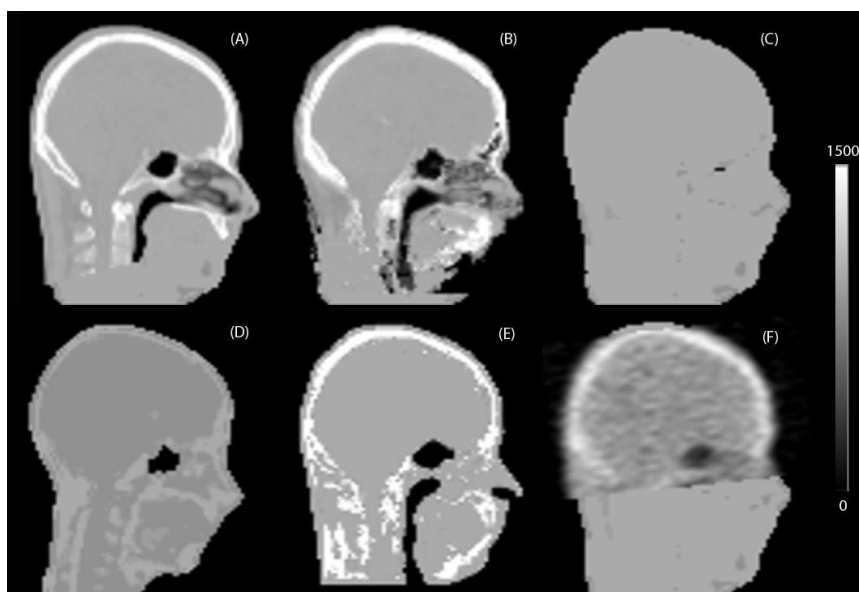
Summary of all presented AC maps: (A) CT, (B) pseudoCT, (C) correct DIXON, (D) DIXON tissue swap, (E) UTE, (F) Transmission with DIXON in neck region.
